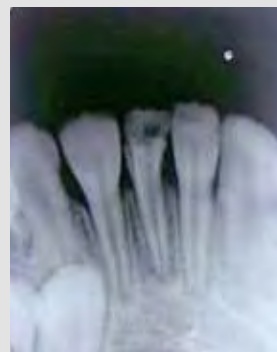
Pre treatment radiograph of dilacerated mandibular central incisor
